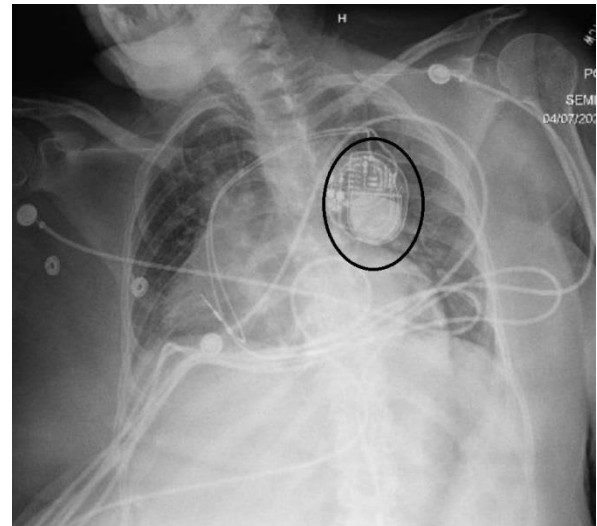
Chest X-ray after dual-chamber pacemaker placement
